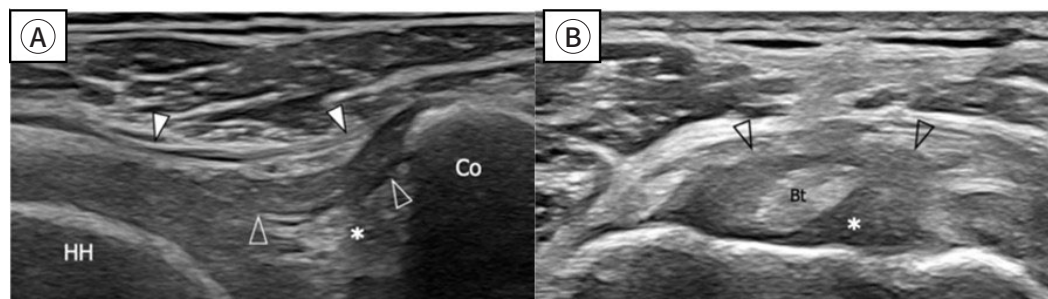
Ultrasonography. Thickened coracohumeral ligament, oblique transverse image (A), short axis image (B). Adapted from Picasso et al. [5] with CC-BY.
